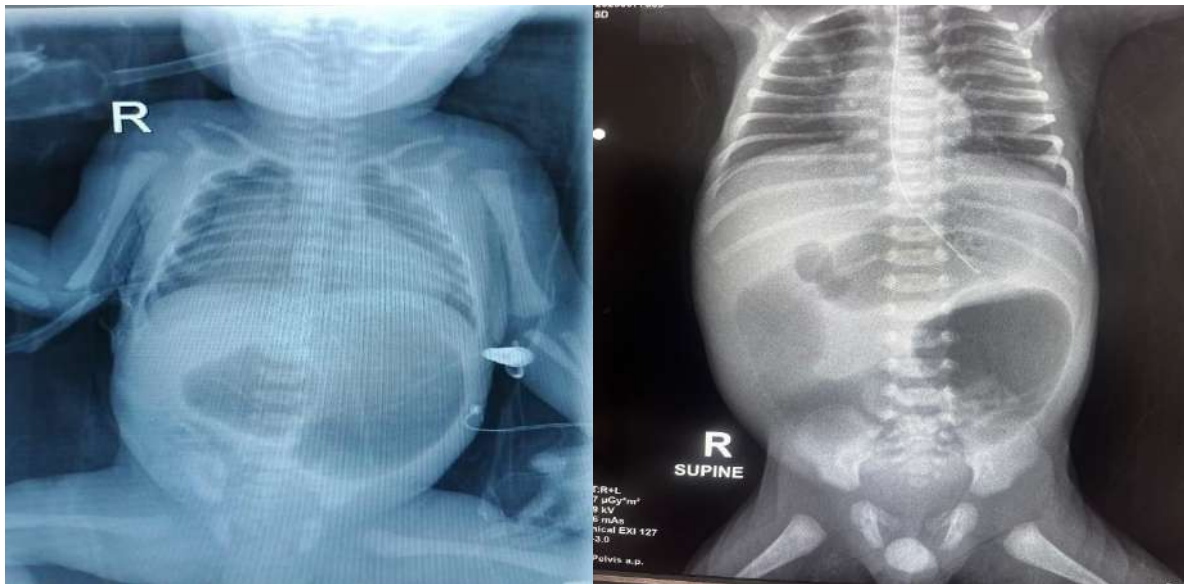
(a&b): (a) Supine X-ray abdomen in a neonate with suspected Perforation peritonitis with “Football Sign”. (b) Lateral X-ray in a sick neonate with free air in abdomen suggestive Perforation peritonitis.
